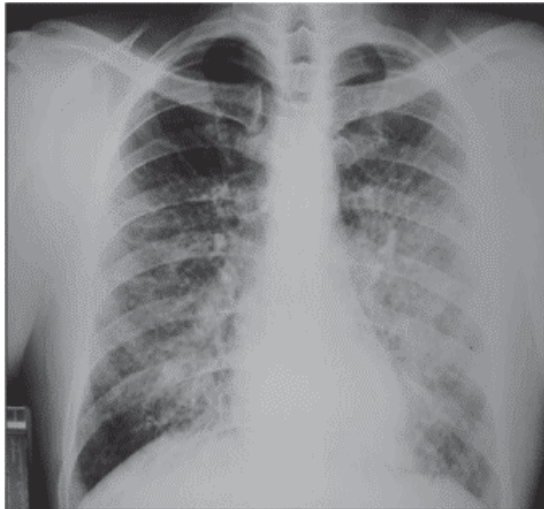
Chest radiograph upon admission to the intensive care unit
